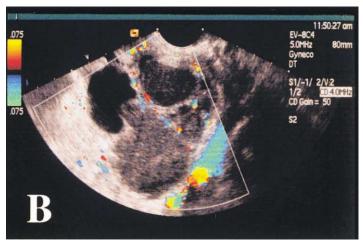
(A) Transabdominal sonography (*transverse view*) of a large endometrioma with "ground glass" appearance (*right*) and anechogenic pseudocysts formed by adhesions (*center* and *left*). The uterus is centrally located (*between crosses*). (B) Transvaginal sonography of a multilocular endometrioma with "ground glass" appearance of cyst contents. Color Doppler imaging enables visualization of limited vascularity in the cyst wall and blood flow in the external iliac vein (*blue color*). The anechogenic cyst represents parts of a hydrosalpinx (*left*).
